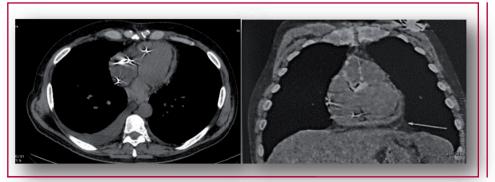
Multislice computed tomography of the chest showing increased pericardial thickening.
